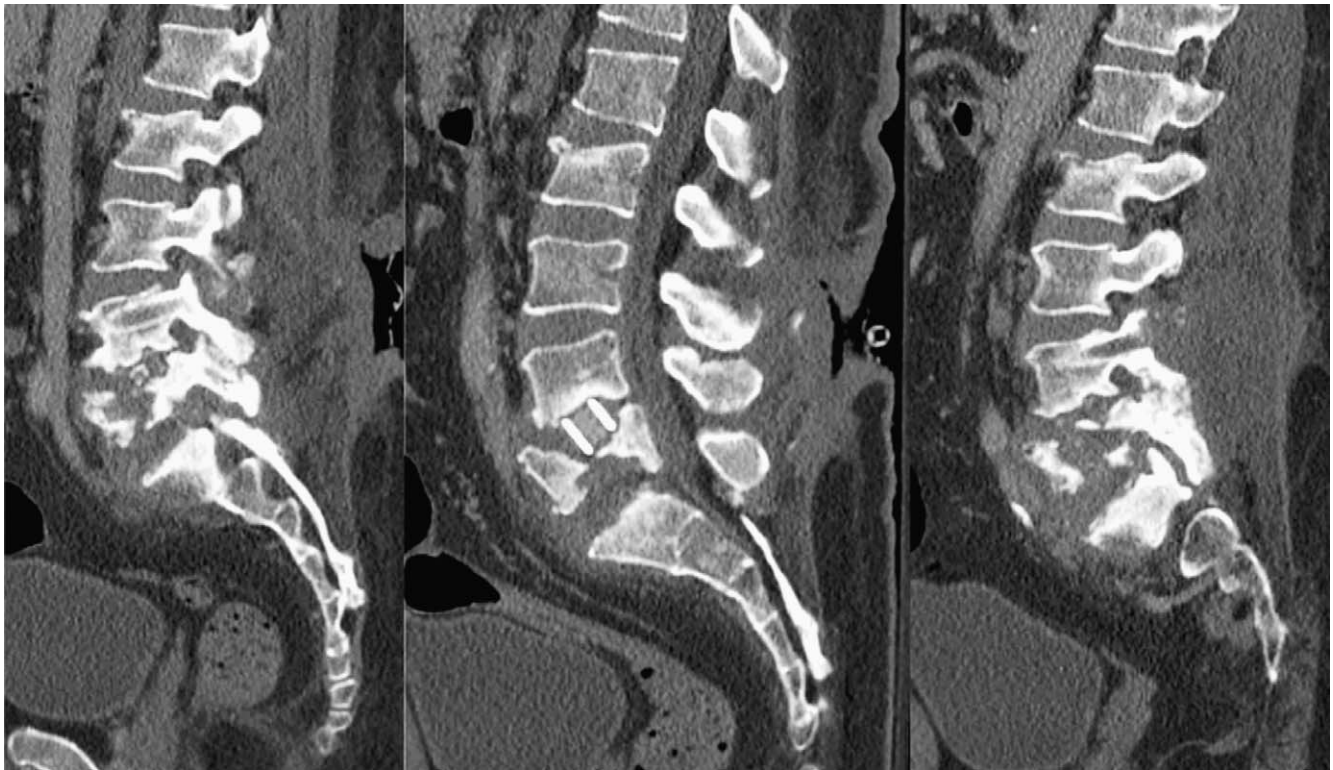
Sagittal computed tomography imaging after removal of the instrumentation showing bone bridging between the inferior L4 and superior L5 facet.
